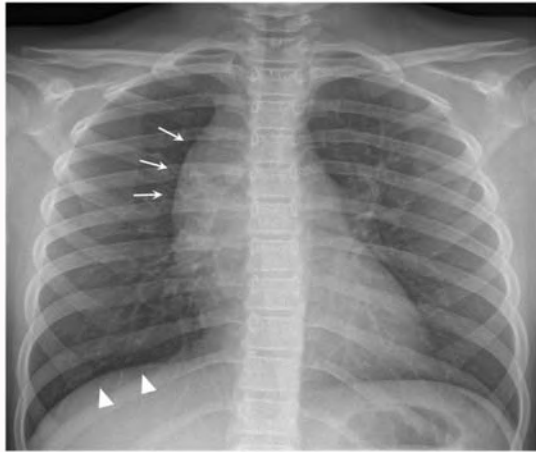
Chest X-ray in posteroanterior (PA) view showing a well-margined mass in the right upper mediastinum (arrows). Intraoperatively it has been found the mass was encasing the right phrenic nerve, which might be related to mildly elevated right hemidiaphragm (arrowheads).
